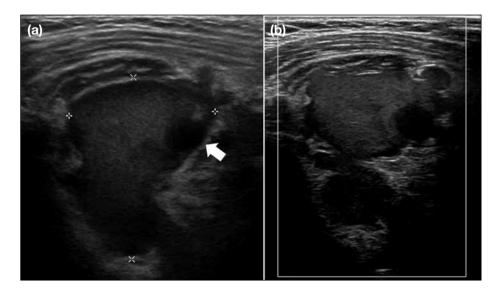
A 6-year-old girl presented with a right anterior chest wall mass after a fall injury. (a) Ultrasound (US) shows a lobulated echogenic lesion with cystic areas (arrow) beneath the right pectoralis major and minor muscles, superficial to the ribcage. (b) Colour Doppler US shows no increased vascularity. Follow-up US (not shown) shows complete resolution of the mass, consistent with haematoma.
